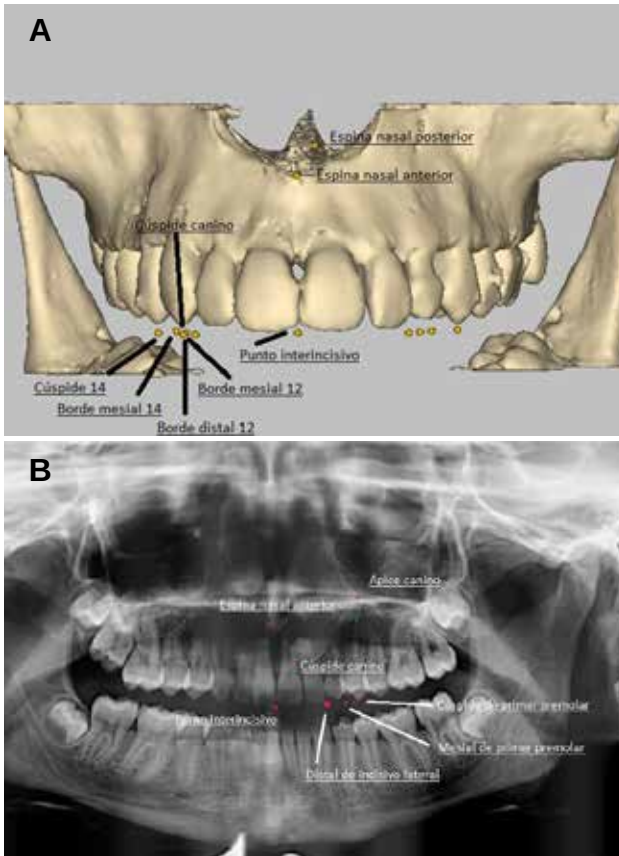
Points marked on CBCT.
